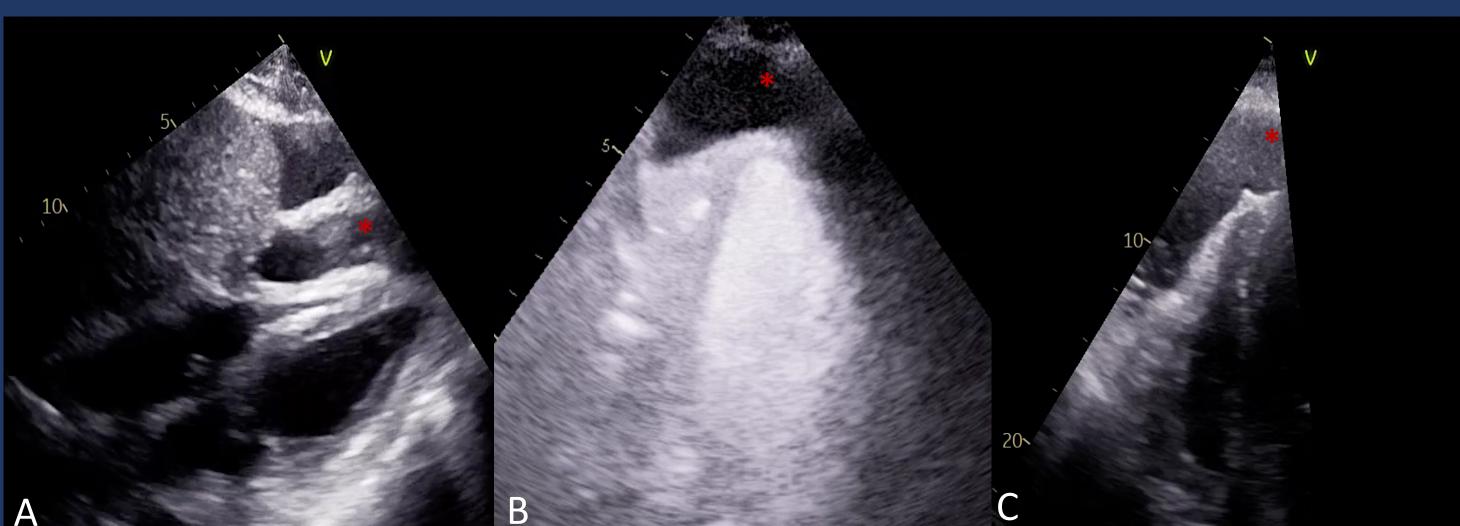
A) Initial TTE subxiphoid view showing the loculated anterior pericardial effusion and tamponade physiology. B) Apical four chamber view with intraventricular contrast study. C) Apical four chamber view again demonstrating tamponade physiology.
